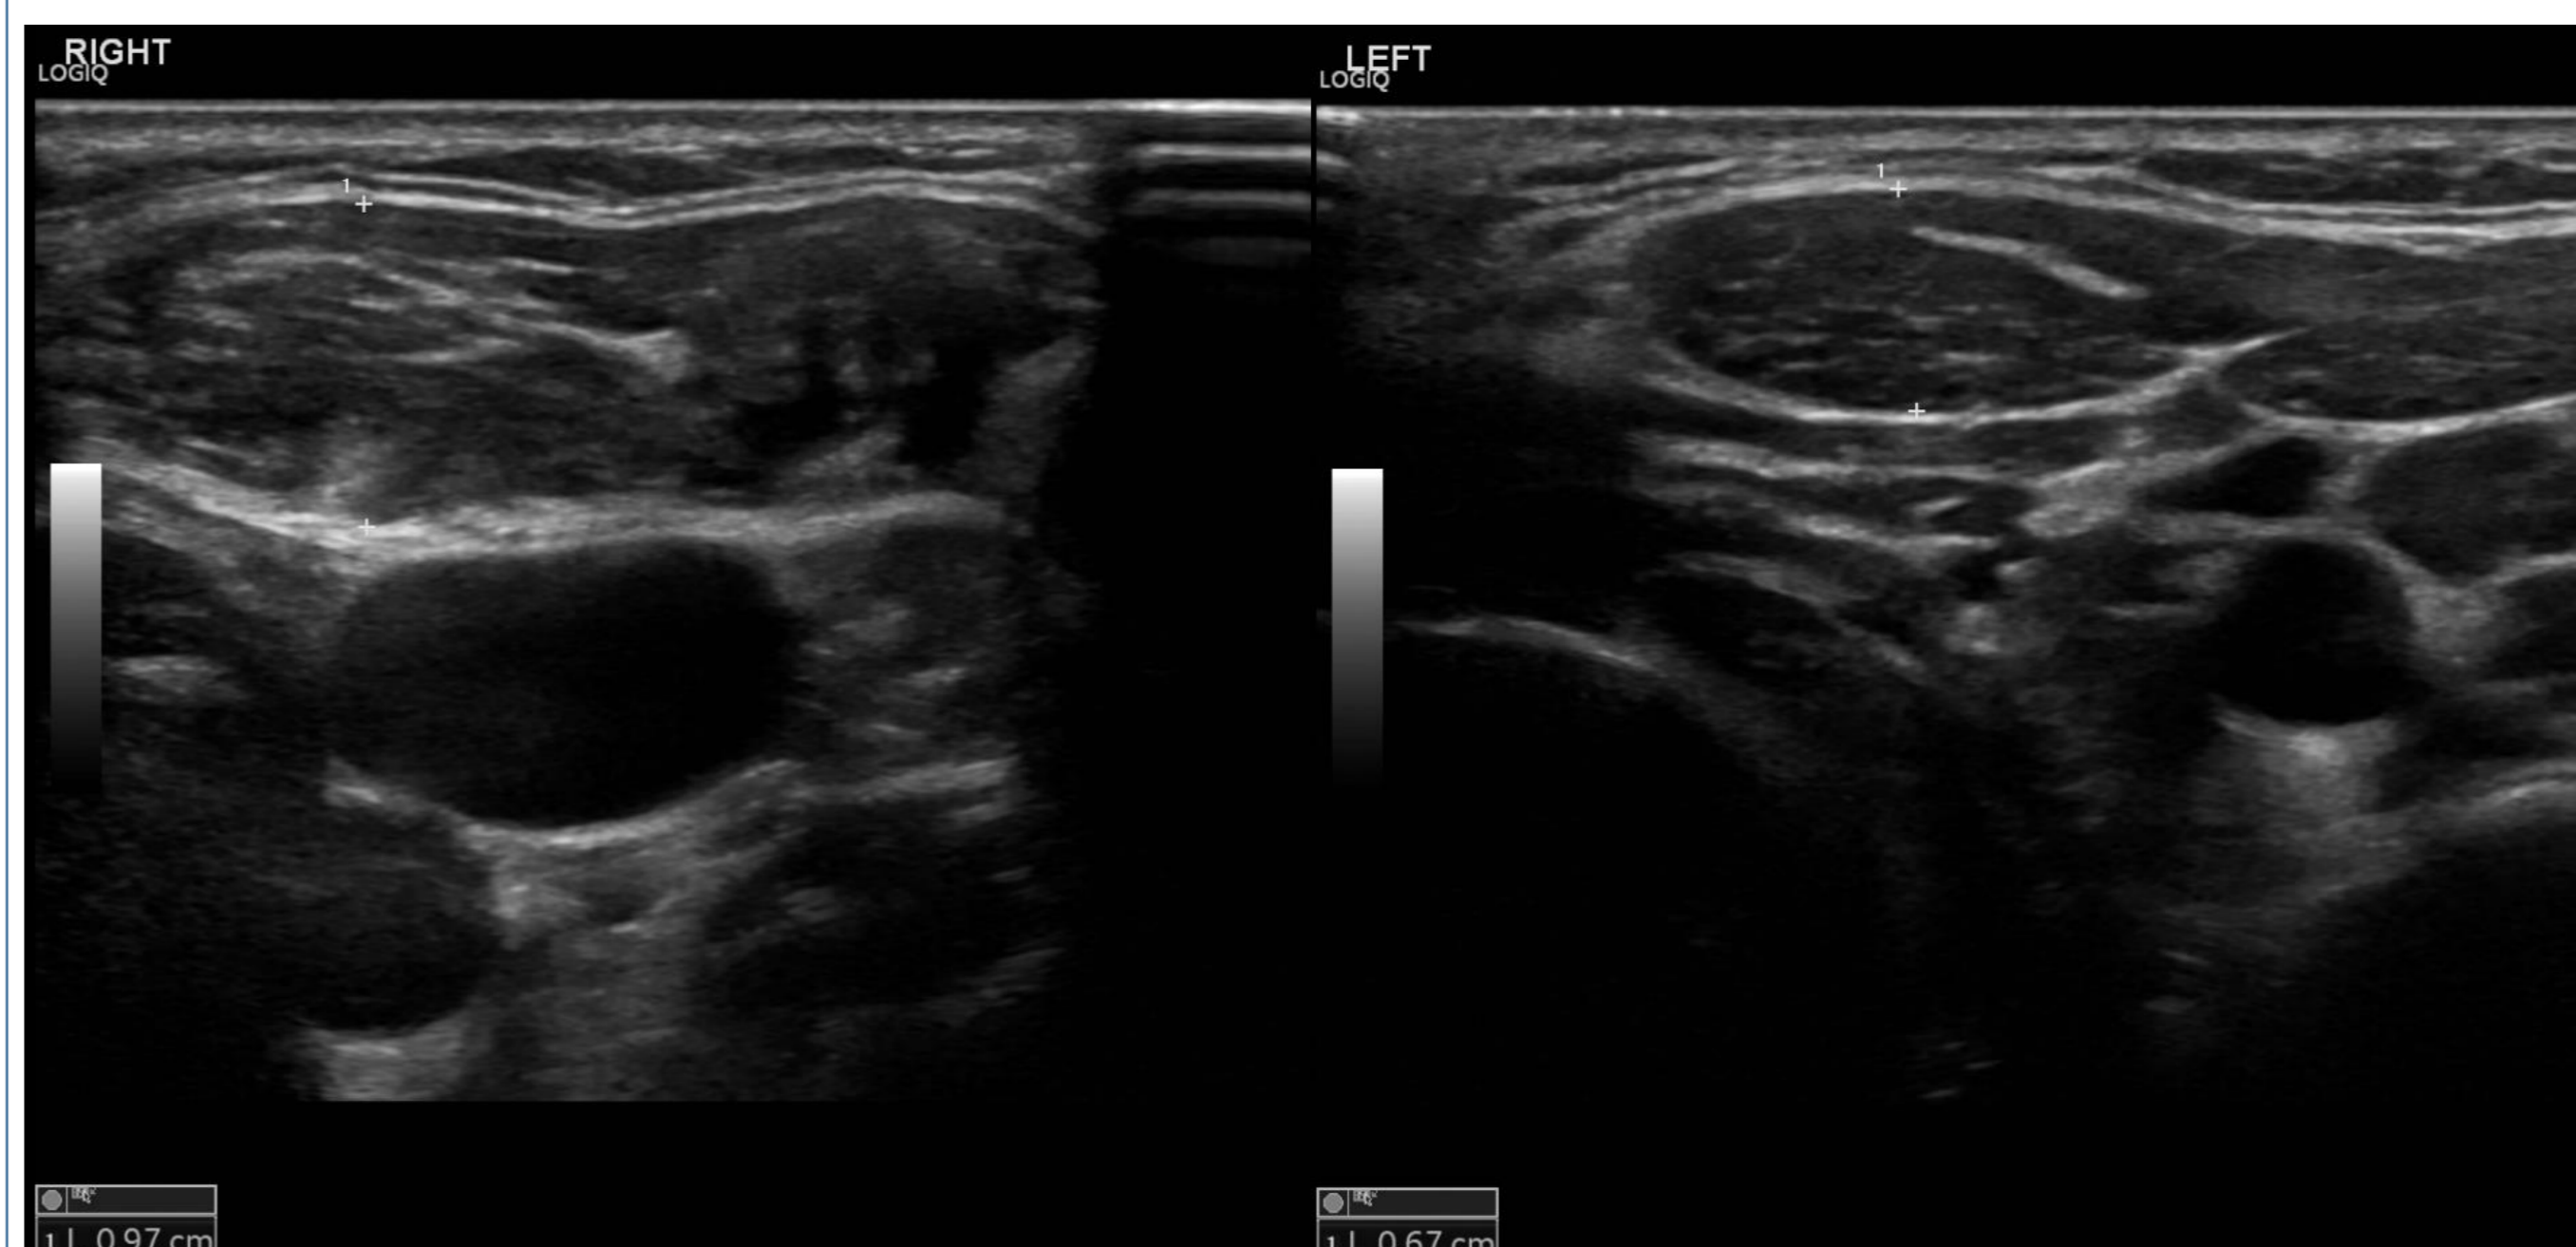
Ultrasonography demonstrates asymmetric thickening of the right sternocleidomastoid muscle (0.97 cm) compared with the left side (0.67 cm), consistent with congenital muscular torticollis.
